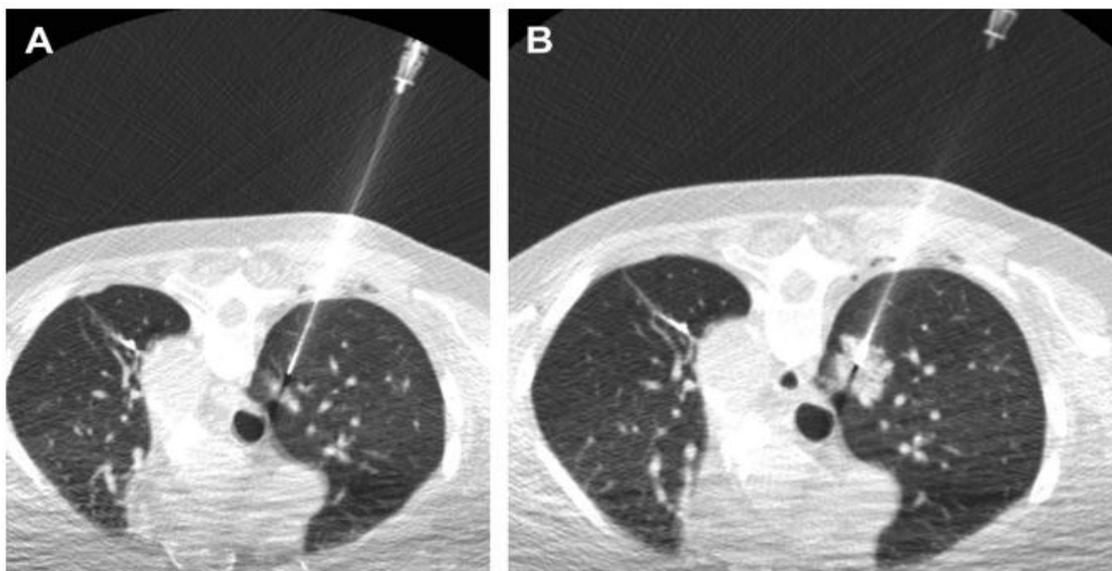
70-year-old man with right upper lobe adenocarcinoma. (A) Axial prone lung window CT image obtained during PTNB shows the coaxial needle proximal to the 1.4-cm nodule. (B) Following FNA, a repeat image shows development of minor pulmonary hemorrhage that obscures the nodule. This hemorrhage may have been caused by the needle tip lying in lung rather than within the lesion at the time of biopsy. The patient was asymptomatic
